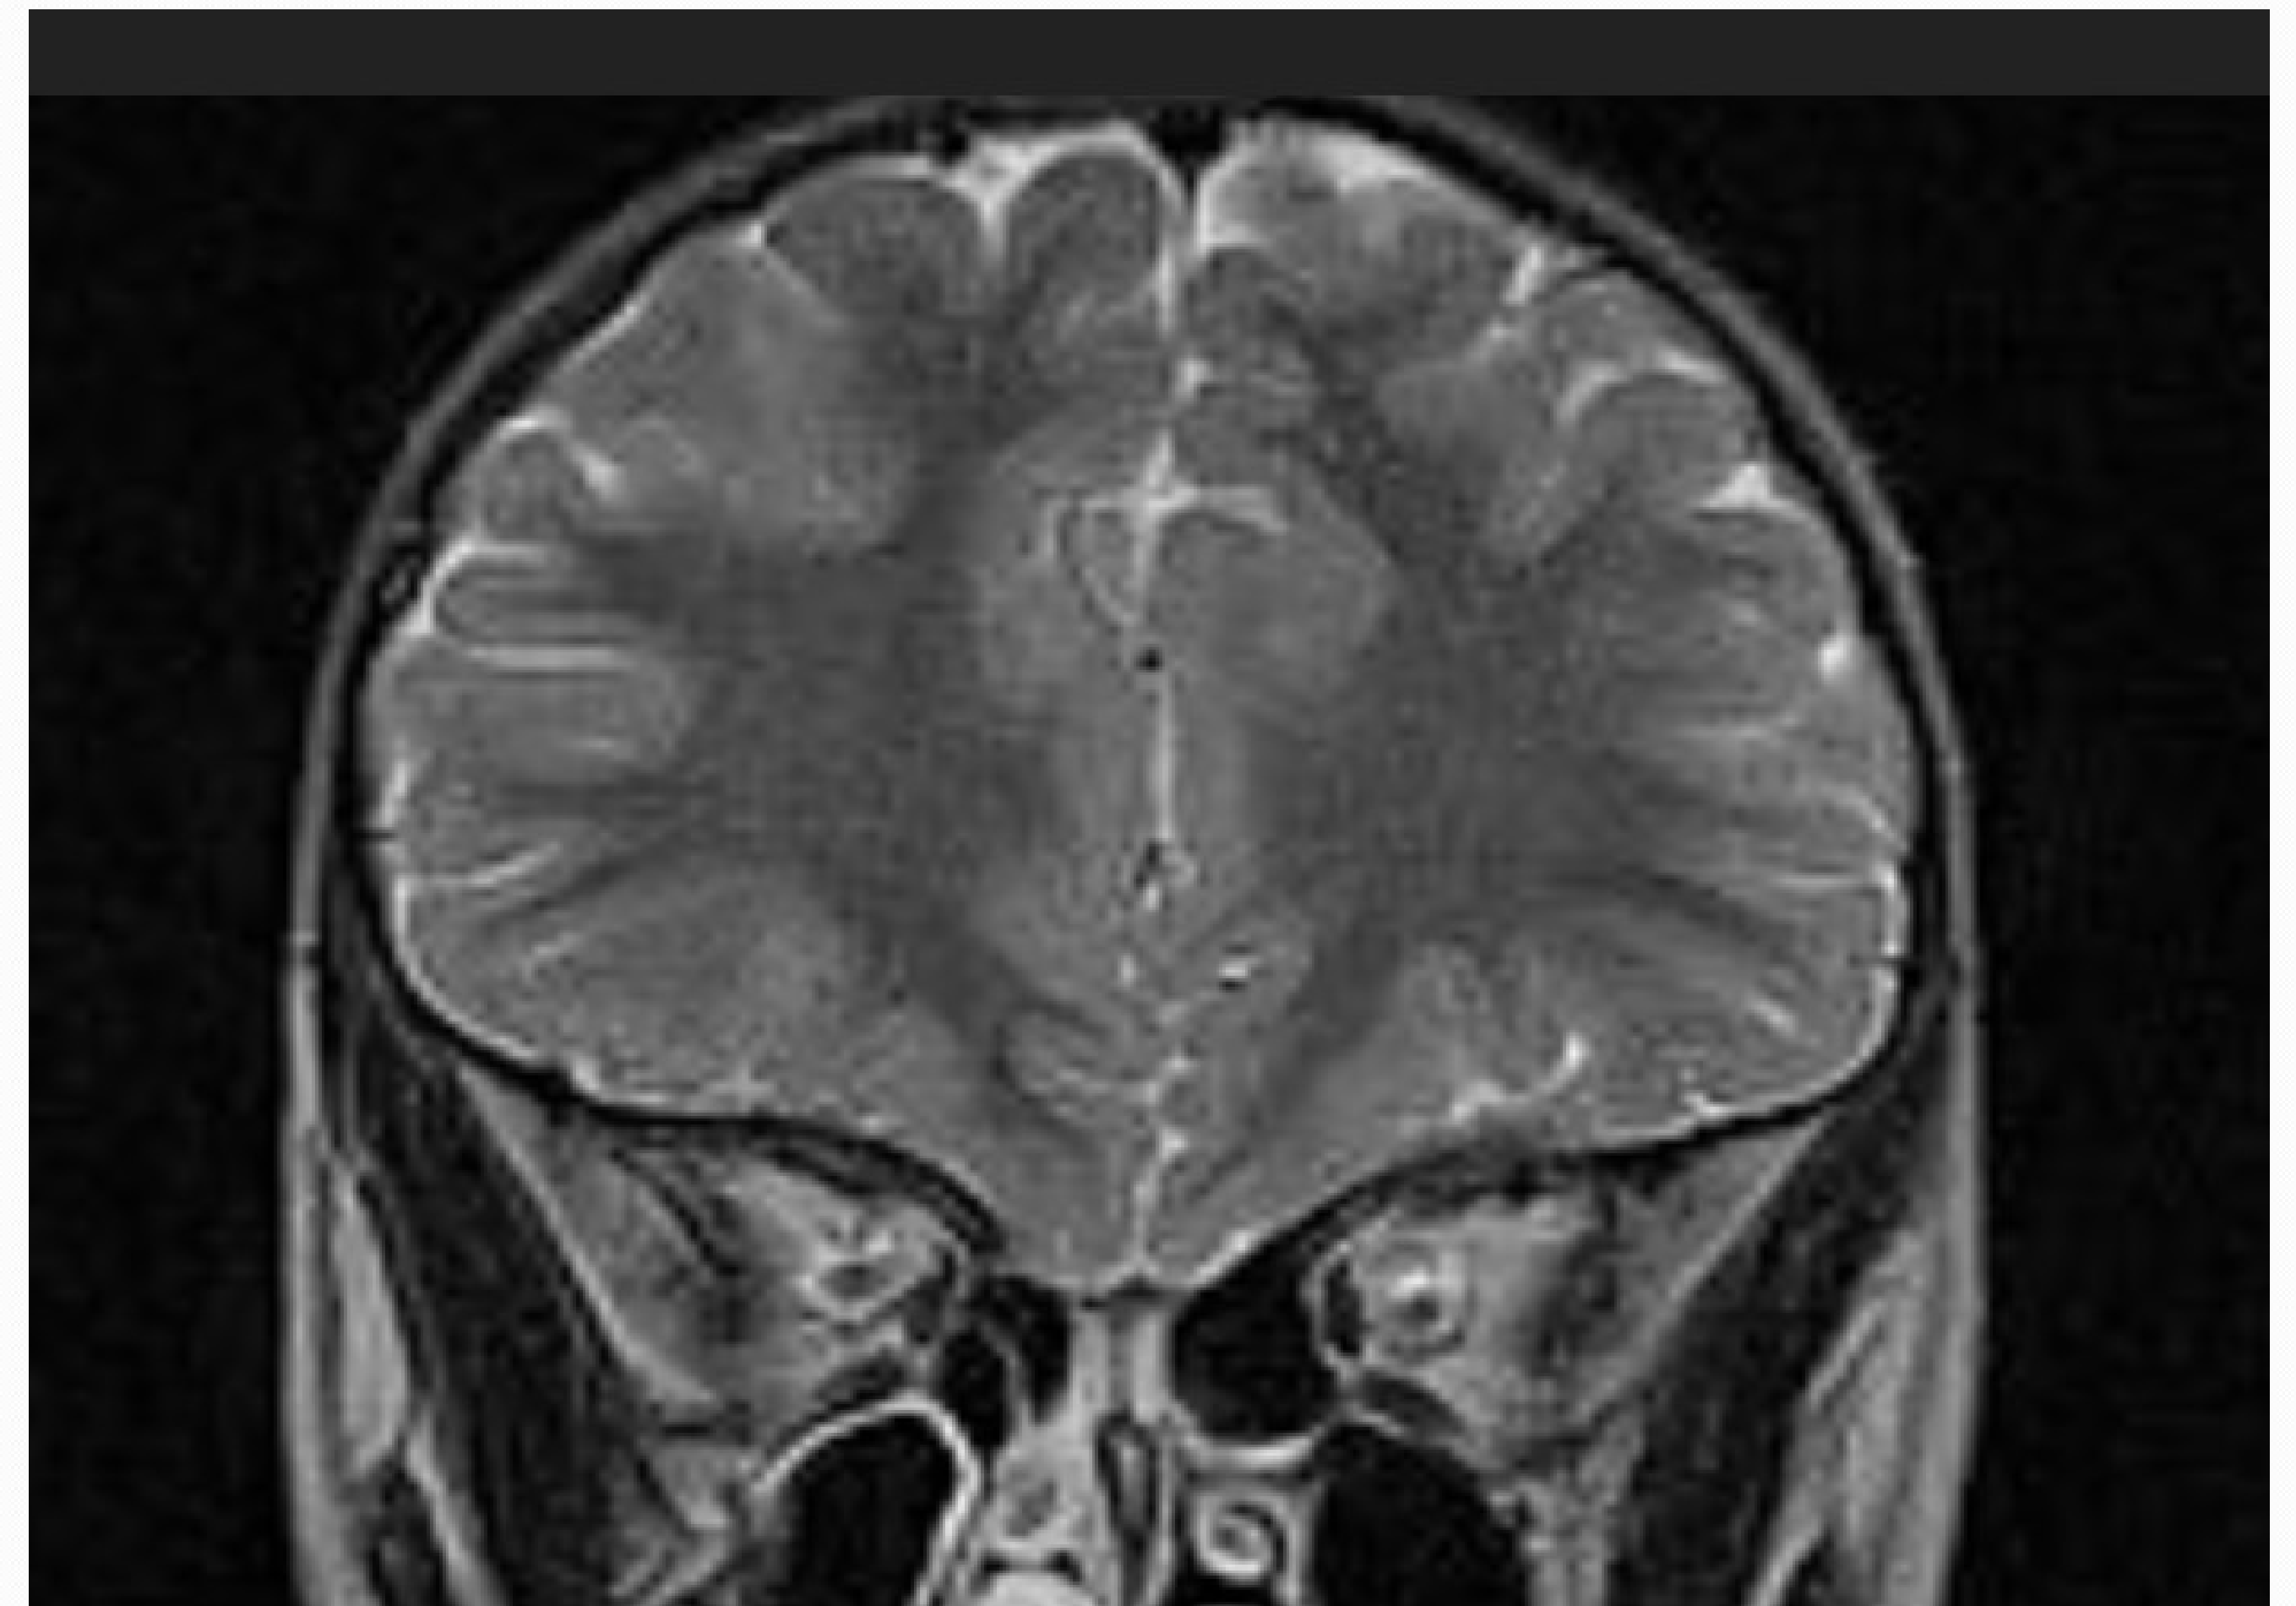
T2-weighted coronal MRI scan, showing olfactory bulbs hypoplasia
